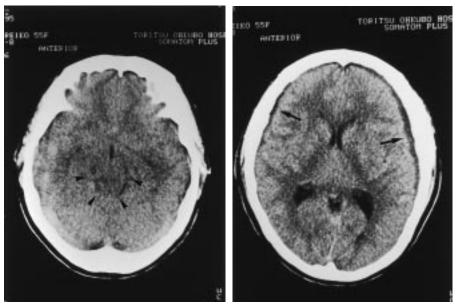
Computed tomography scans without contrast infusion show obliteration of the perimesencephalic cistern (arrowheads) and of the Sylvian fissures (left), and the presence of subdural fluid collections (arrows) on both sides (right). The computed tomography density of the subdural fluid is high relative to that of cerebrospinal fluid
